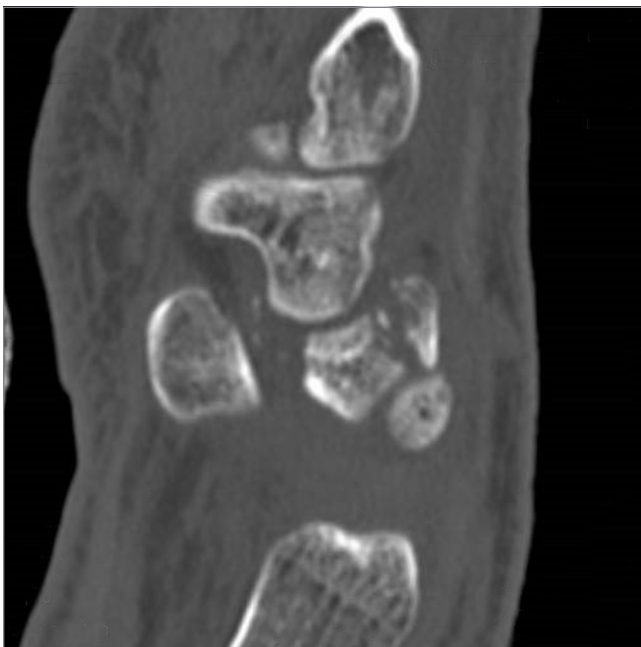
Computed tomography shows displaced triquetral fracture.
